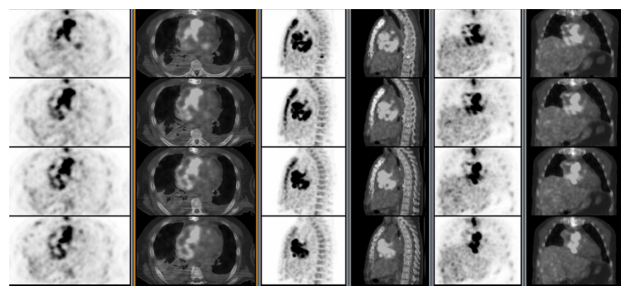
¹⁸F-FDG PET-CT image showing the tumor mass in the right atrium. Abbreviations: CT, computed tomography; FDG, fluorodeoxyglucose; PET, positron emission tomography.
